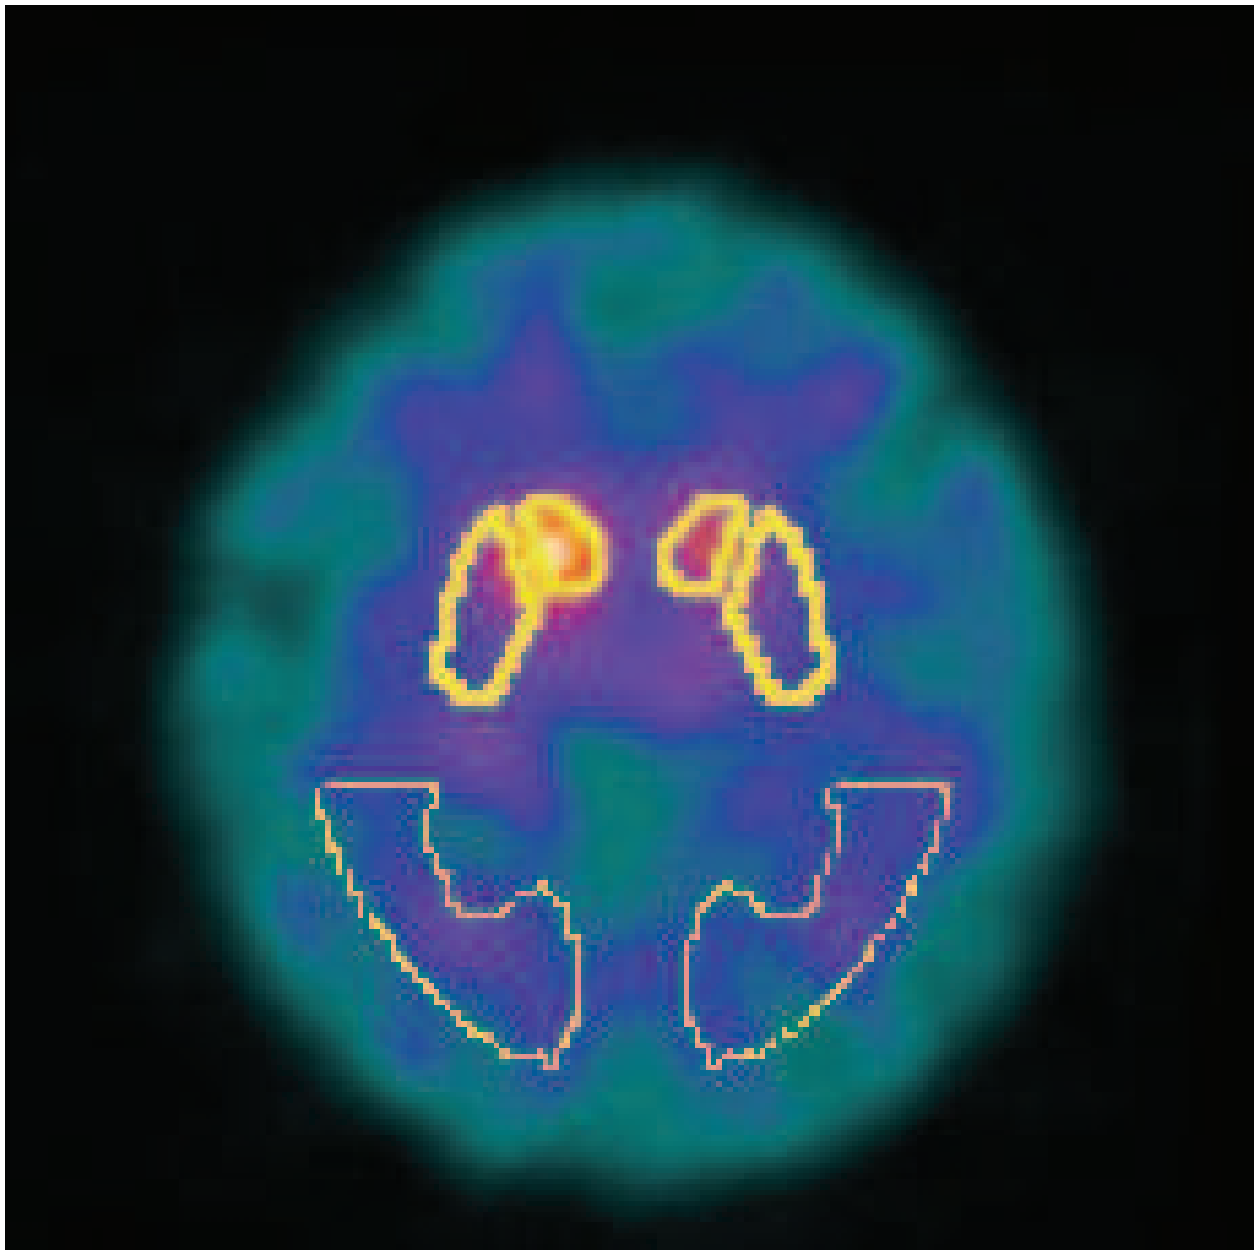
FP-CIT SPECT in a patient with PD of the hypokinetic rigid type. The striatal FP-CIT uptake is bilaterally more reduced than in Figure 1.
